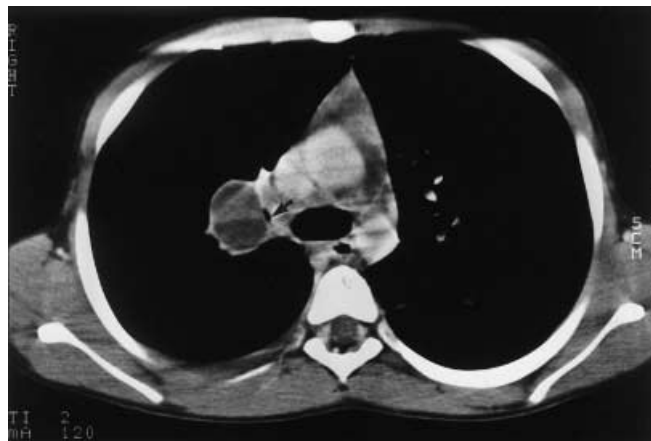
CT scan of the chest demonstrates a low-density mass in the right supra-hilar region inseparable from the mediastinum. Note the close proximity of the mass to a portion of the right upper lobe bronchus (arrow)
